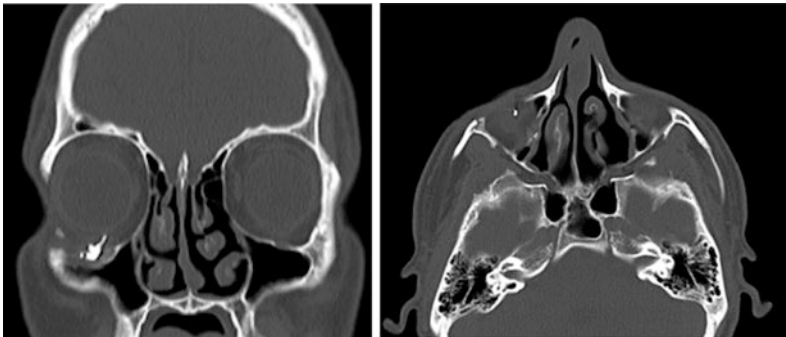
Intraorbital foreign body in a 37 years old male with history of previous gun injury in the right eye. a–b coronal reformatted and axial CT images in bone window demonstrate fracture of the inferior and lateral walls of the right orbit with extraconal small dense foreign body (shrapnel)
